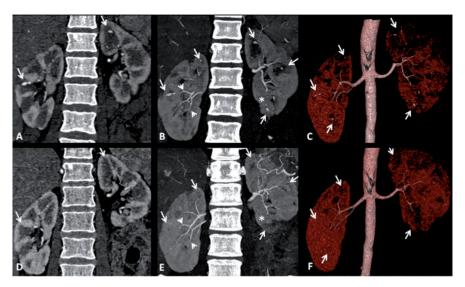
CT and CT angiography of the kidneys. Arterial phase contrast-enhanced coronal CT (A and D), CT angiography using Maximum Intensity Projection (B and E) and three-dimensional CT angiography using volume rendering reconstructions (C and F). Images at the time of diagnosis show multiple artery microaneurysms in both kidneys (arrows) (A-C) and stenotic lesions (short arrows) and a proximal occlusion (asterisk) (B). Sixteen months after starting treatment, microaneurysms are not visualised (D-F).
